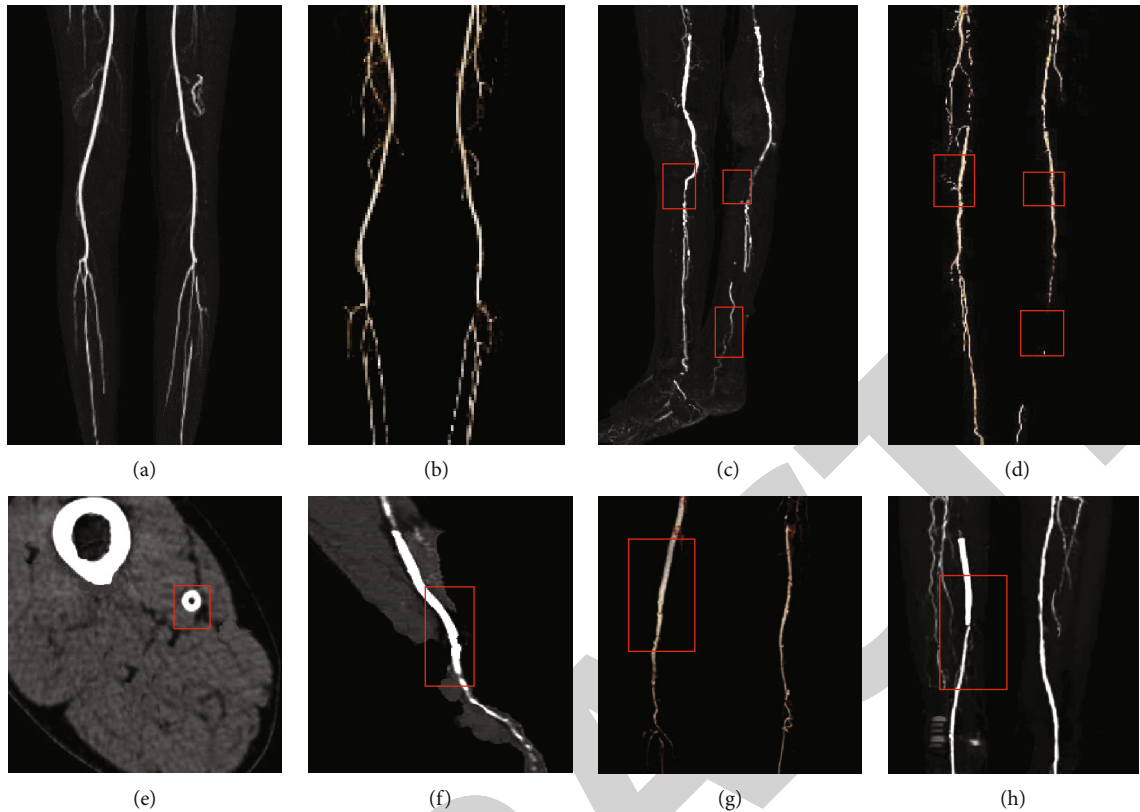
Comparison of MSCTA imaging processing before and after stent implantation in patients with lower extremity arterial occlusion. The marked part in red indicated the narrow part of the lower limb artery. (a, b) The imaging results of blood vessels of healthy volunteers. (c, d) The imaging results of the blood vessels of patients. (e) The CT plain scan results. (f) The CTA surface reconstructed image. (g) The image after boneless volume reconstruction. (h) The image constructed by the maximum density projection.
